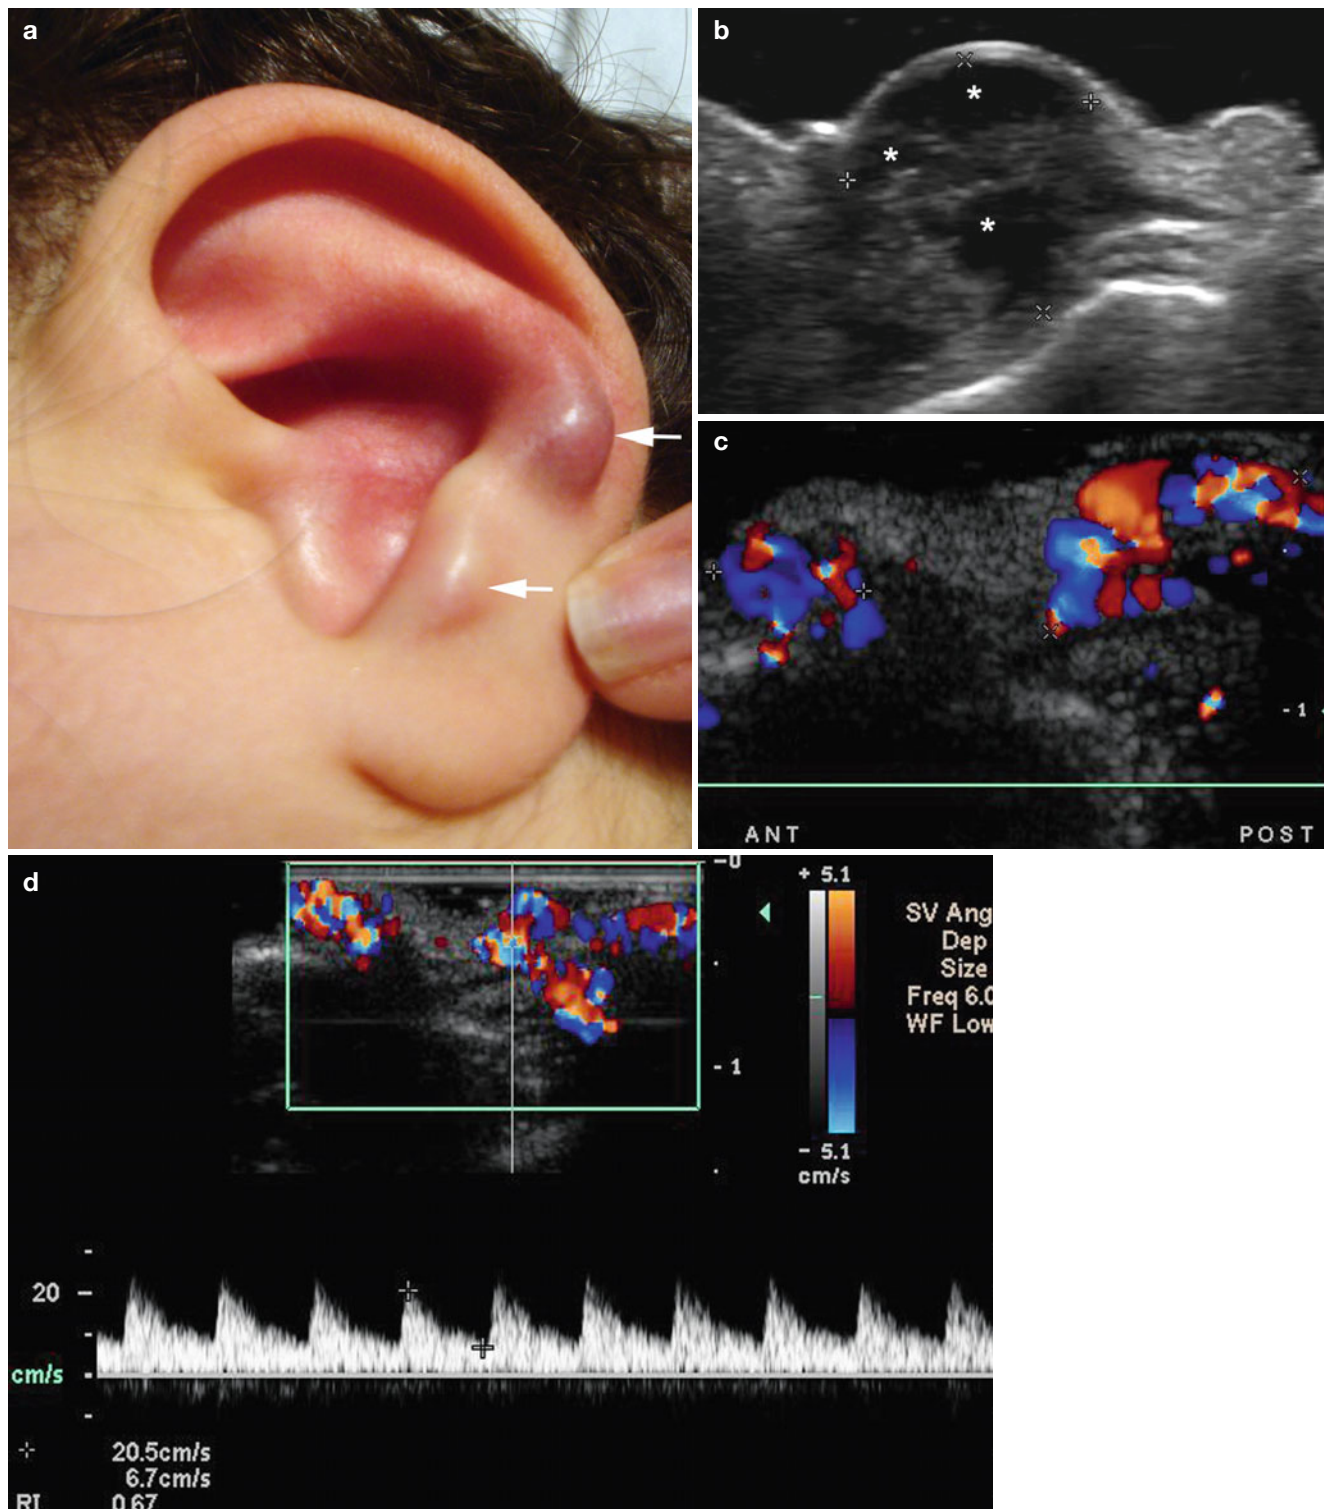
(a–d) Arterial vascular malformation. (a) Clinical image of a patient presenting with two erythematous bumps in the left ear pinna. (b) Ultrasound image (gray scale, transverse view) at the most lateral and large bump demonstrates hypoechoic lesion (between markers) with anechoic tubular and pseudocystic areas (*) that partially involves
